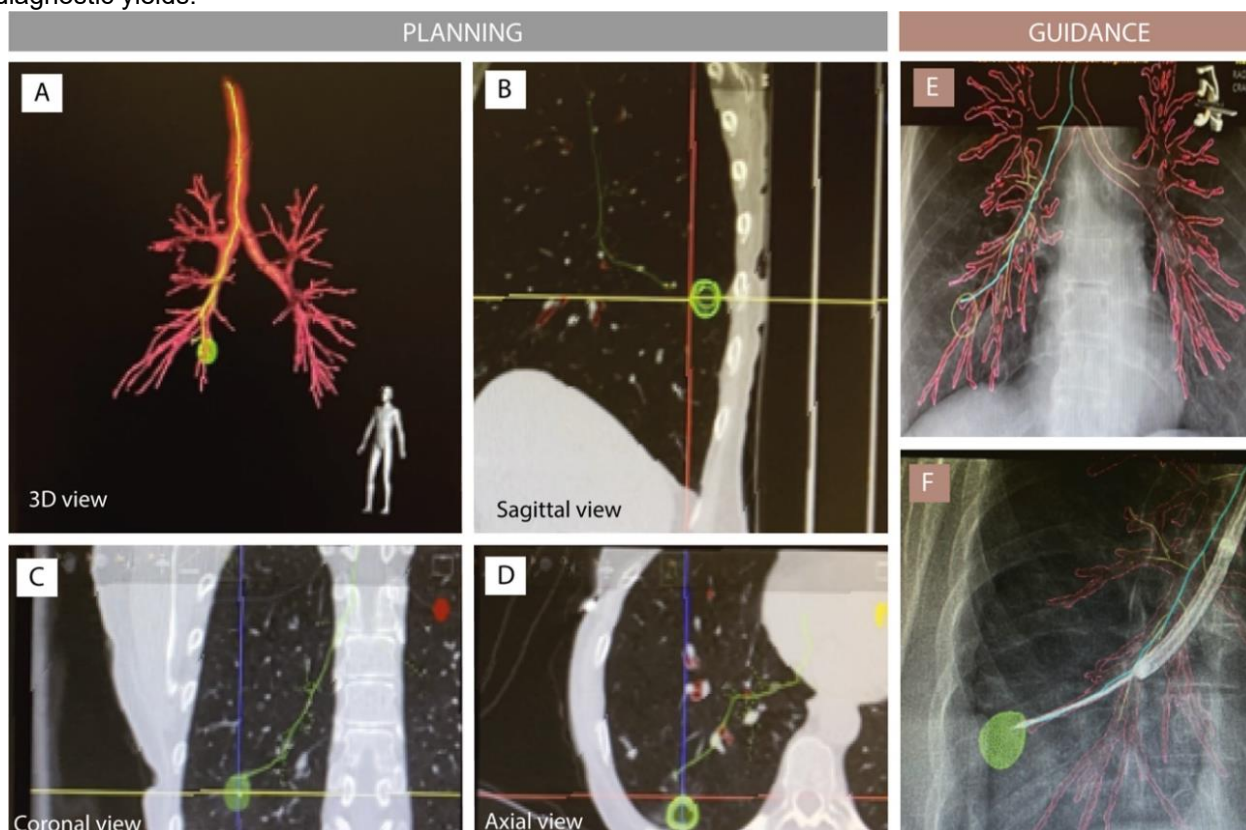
CBCT guidance in bronchoscopy with advanced software tools for peri-procedural planning and 3D image-guidance (AirWaze investigational device, version 1.0). After 3D segmentation of the target lesion and the bronchial tree on pre-operative CT data, the virtual pathway to the target nodule was generated (A-D). Automatic elastic registration of the pre-operative CT with intraprocedural CBCT data enabled live guidance with augmented fluoroscopy views of the airways and virtual pathway to the segmented target lesion I. Confirmation of tool-in-lesion (F).
